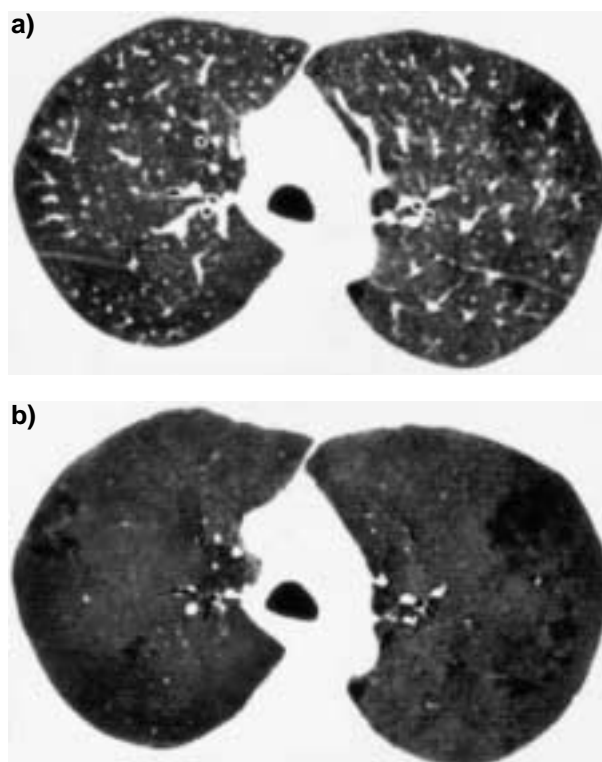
A 40-yr-old patient with a history of cigarette smoking. a) High-resolution computed tomography shows pulmonary emphysema (window width, 480 Hounsfield units (HU), window level, -720 HU). b) Sliding thin slab, minimum intensity projection (slab of seven 1-mm sections) at the same level and same window width and level increases the difference between normal and emphysematous lung. Note that peripherally located vessels are not displayed as clearly as on figure 3a.
